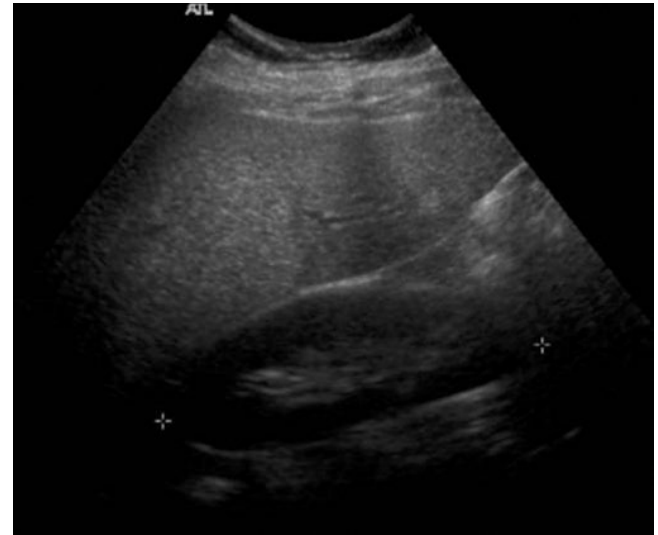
Sonogram of the liver in non-alcoholic fatty liver disease (NAFLD) demonstrates hyperreflectivity, suggestive of fatty infiltration. It should be noted how bright the liver is in comparison with the kidney. This is not specific for NAFLD, as similar appearances may be found in cystic fibrosis. Serial liver ultrasound examinations may demonstrate progression (or regression) of the disease.
